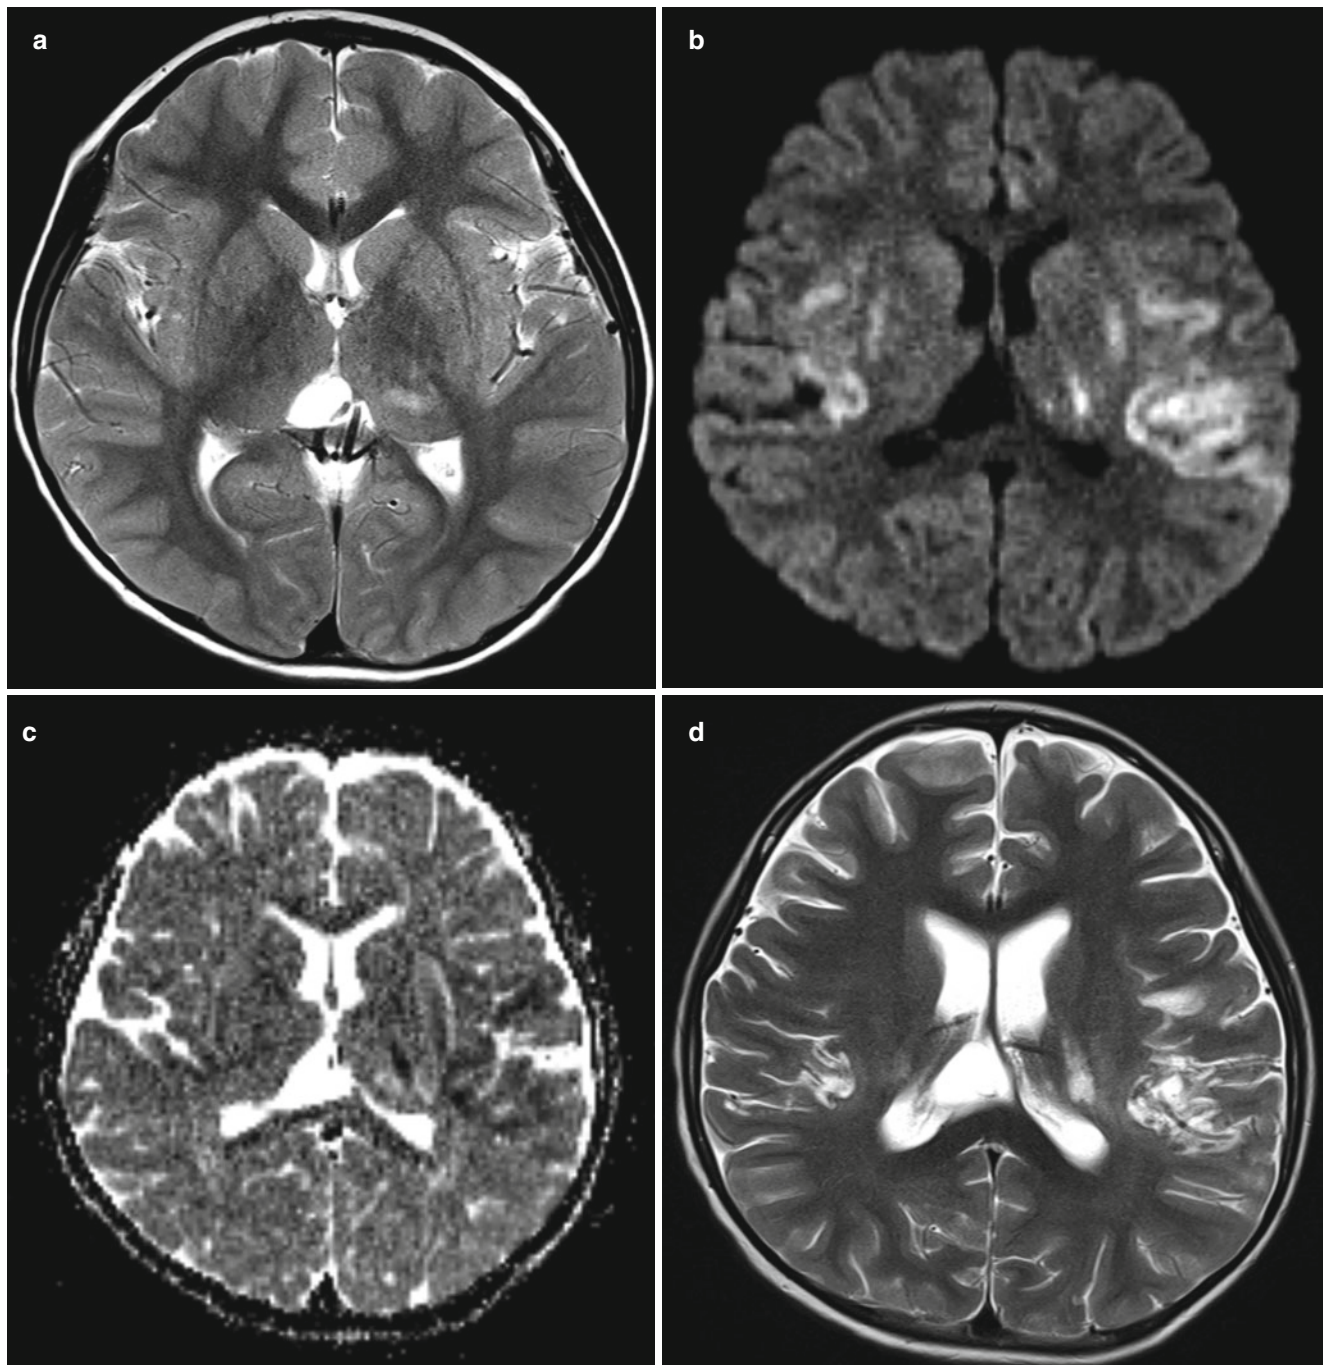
A 5-year-old boy with herpes simplex encephalitis. (a) T2-weighted image shows subtle swelling of the temporal lobe and thalamus and posterior cingulate gyrus, predominantly in the left side. (b) Diffusion and ADC (c) images after 3 days show restricted diffusion
